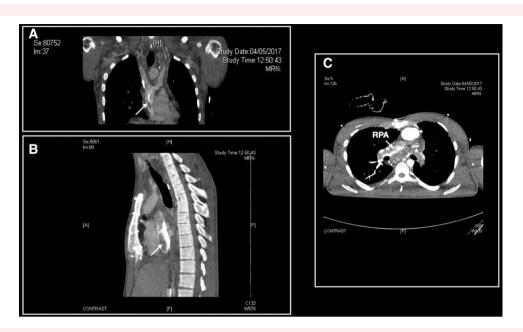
Axial delayed-phase computed tomography pulmonary angiogram shows the filling defect of extra-cardiac Fontan conduit (arrows) indicating the presence of thrombosis (*A* and *B*). Unopacified left pulmonary artery (*) and irregular endoluminal contour of the right pulmonary artery (arrow) are suggestive of pulmonary emboli (*C*).
